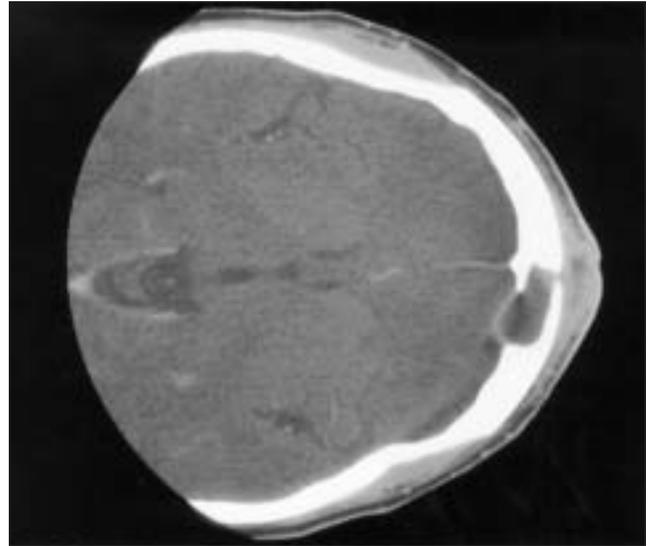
Contrast-enhanced computed tomography scan demonstrating subgaleal abscess, erosion of anterior and posterior wall of left frontal sinus and small epidural fluid collection
